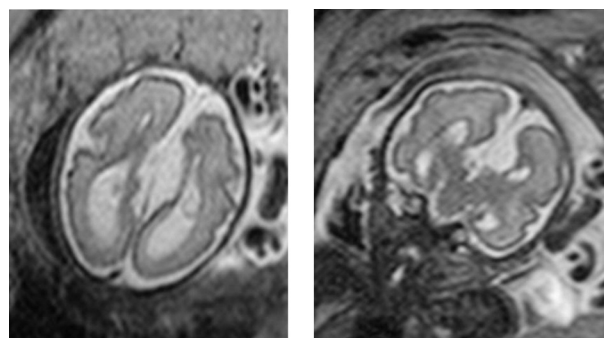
T2-weighted images, gestational age 28 weeks: corpus callosum agenesis with colpocephaly in axial (left) and coronal plane (right) with associated interhemispheric cyst.
